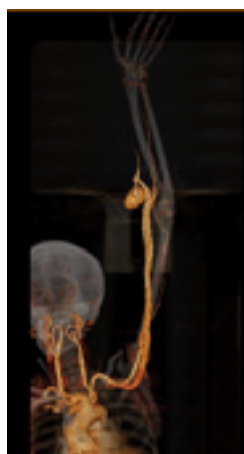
Three-dimensionally reconstructed CT angiography scan. A large outpouching from AV fistula (brachial artery and cephalic vein) is seen on the anterolateral aspect of the left elbow joint suggestive of pseudoaneurysm
